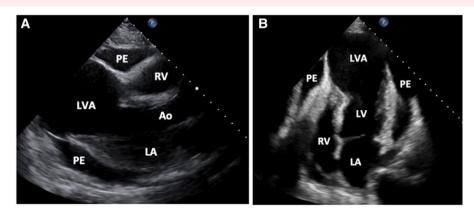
Admission parasternal long (A) and apical four-chamber (B) TTE images displaying the large LV aneurysm (LVA) and surrounding pericardial effusion (PE).
